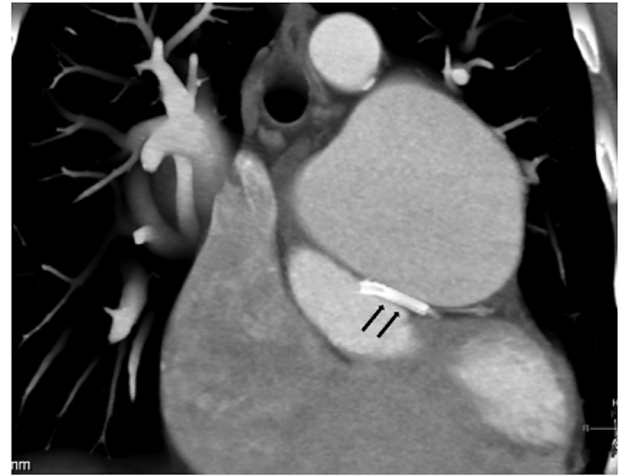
Follow-up Computed Tomography. Black arrows show adequate LMCA stent expansion without external compression. LMCA: left main coronary artery.
